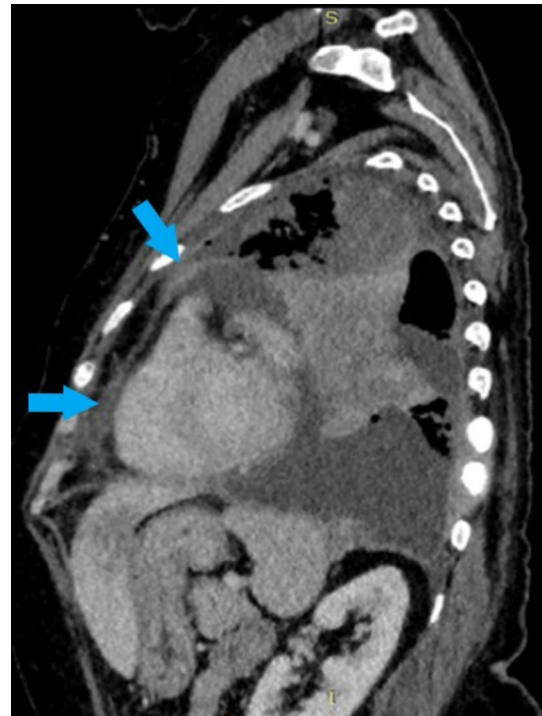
Sagittal chest CT shows anterior and superior pericardial wall thickening (blue arrow)
